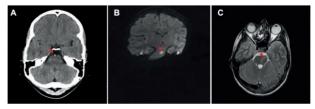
Initial radiological evaluation of 13-year-old girl at the emergency department confirming acute ischemic stroke. A) Computed tomography axial scan showing basilar artery spontaneous hyperdense lesion. B) Magnetic resonance imaging diffusion coronal image showing hyperintense pons lesion, further complemented with C) Magnetic resonance imaging T2 axial scan showing also hyperintense pons lesion. Red arrows indicate lesions.
